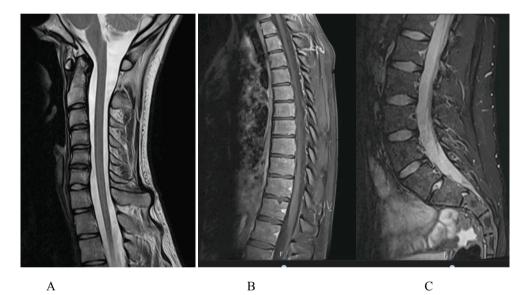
Sagittal magnetic resonance imaging of cervical (A), thoracic (B) and lumbosacral (C) spine showing no leptomeningeal tumor spread.
